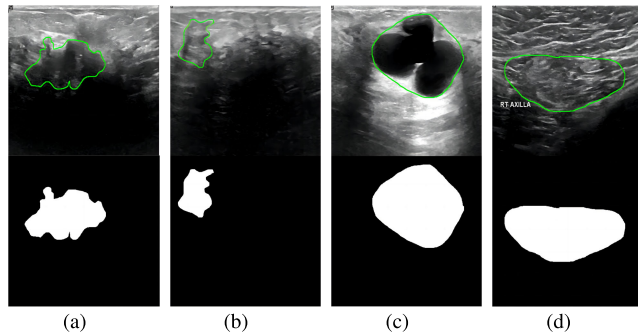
Examples of different disadvantages in breast tumor ultrasound images, (a) and (b) are ultrasound images of malignant tumors with irregular borders and shapes, (c) is ultrasound images of benign tumors with uneven shapes, and (d) is large motion artifact images ultrasound image of a benign tumor. Tumor boundaries are indicated in green. The images in the second row is the groundtruth of tumors.
